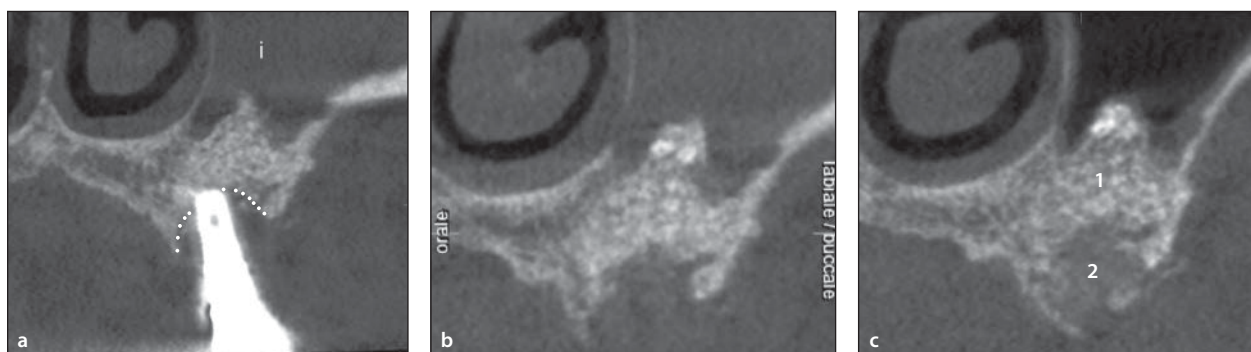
(a) The bone defect (dotted line) extends up to 2 or 3 mm from the implant apex with significant inflammation (i) of the sinus membrane, but the OMC is patent (not visible on this cut). (b) CBCT immediately after implant removal. (c) CBCT taken 8 months after implant removal. Residual graft is present (1). The defect is completely healed (2), and the sinus membrane shows no more thickening.
